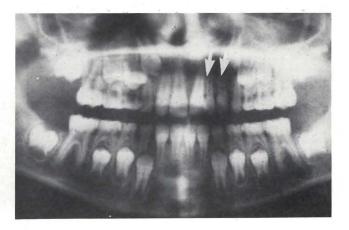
A radiograph of a nine-year-old female, with twinning of the left maxillary lateral incisor.
